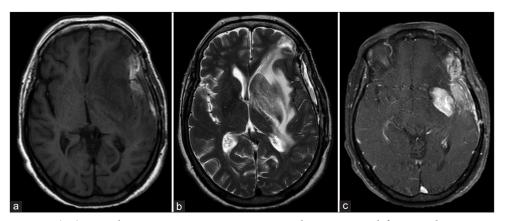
(a-c) Control magnetic resonance imaging 2-month post-surgery: left pterional craniotomy with extra-axial residual blood collection. Partially resected infiltrative left temporal lesion with extension to the frontal and parietal lobes. Persistent contrast-enhancing lesion with mass effect on the left lateral ventricle.
